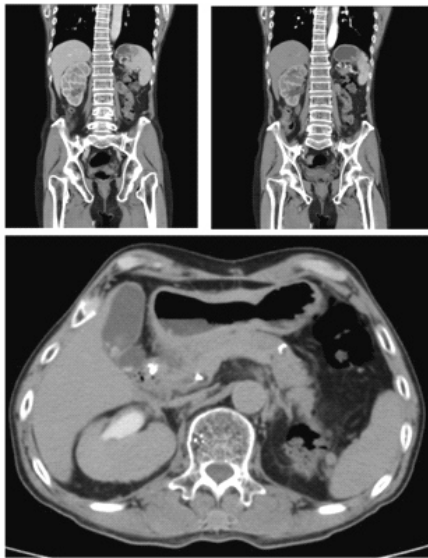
CT Scan in April 2022 showed no tumor mass present in the right pelvicalyceal system
